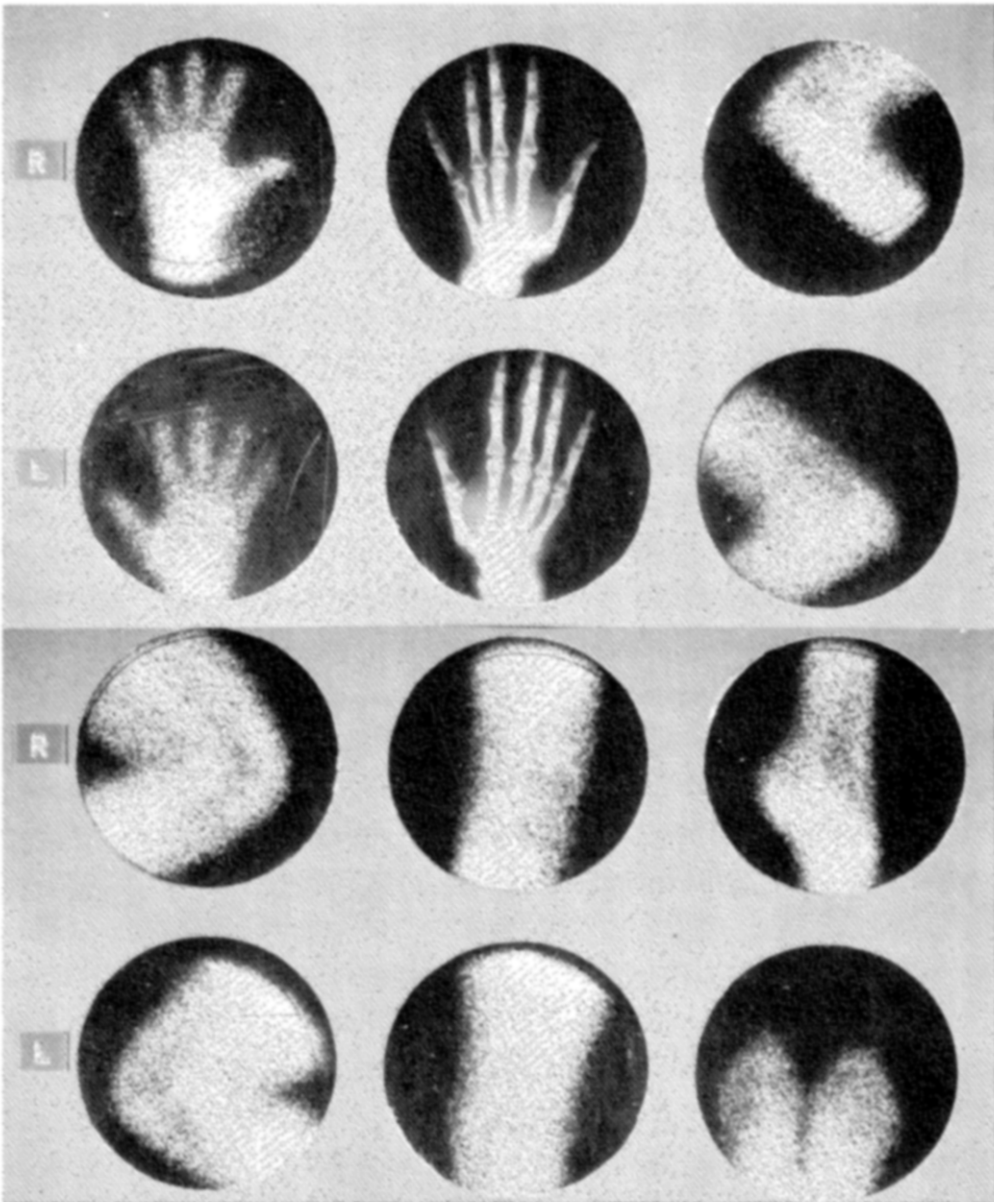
Osteoarthritis usually shows positive synovial membrane scan only in areas where there is evidence of osteoarthritis on roentgenograms. This patient complained of pain at base of right thumb. Roentgenogram and $^{99m}\text{TcO}_4$ were both positive in this area and other joint areas were normal on both studies.
